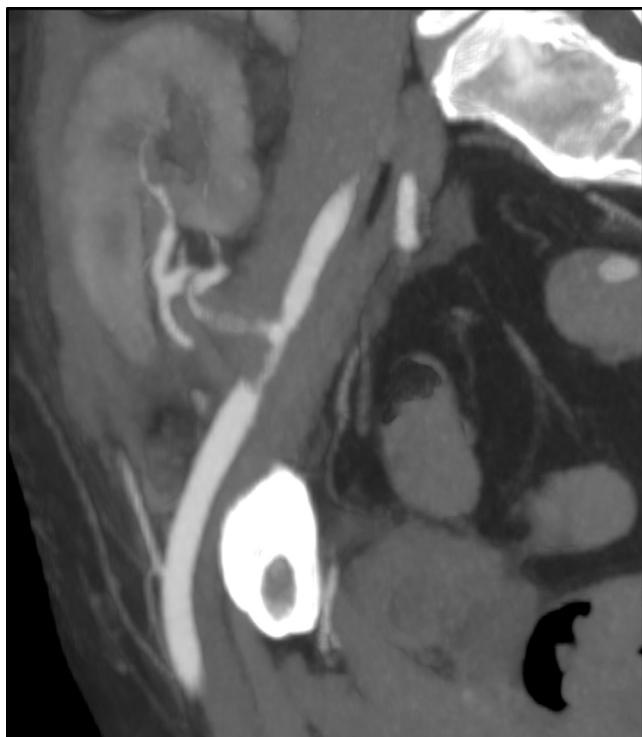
Preoperative computed tomography angiogram showing partial thrombosis of the right external iliac artery and transplant renal artery.
